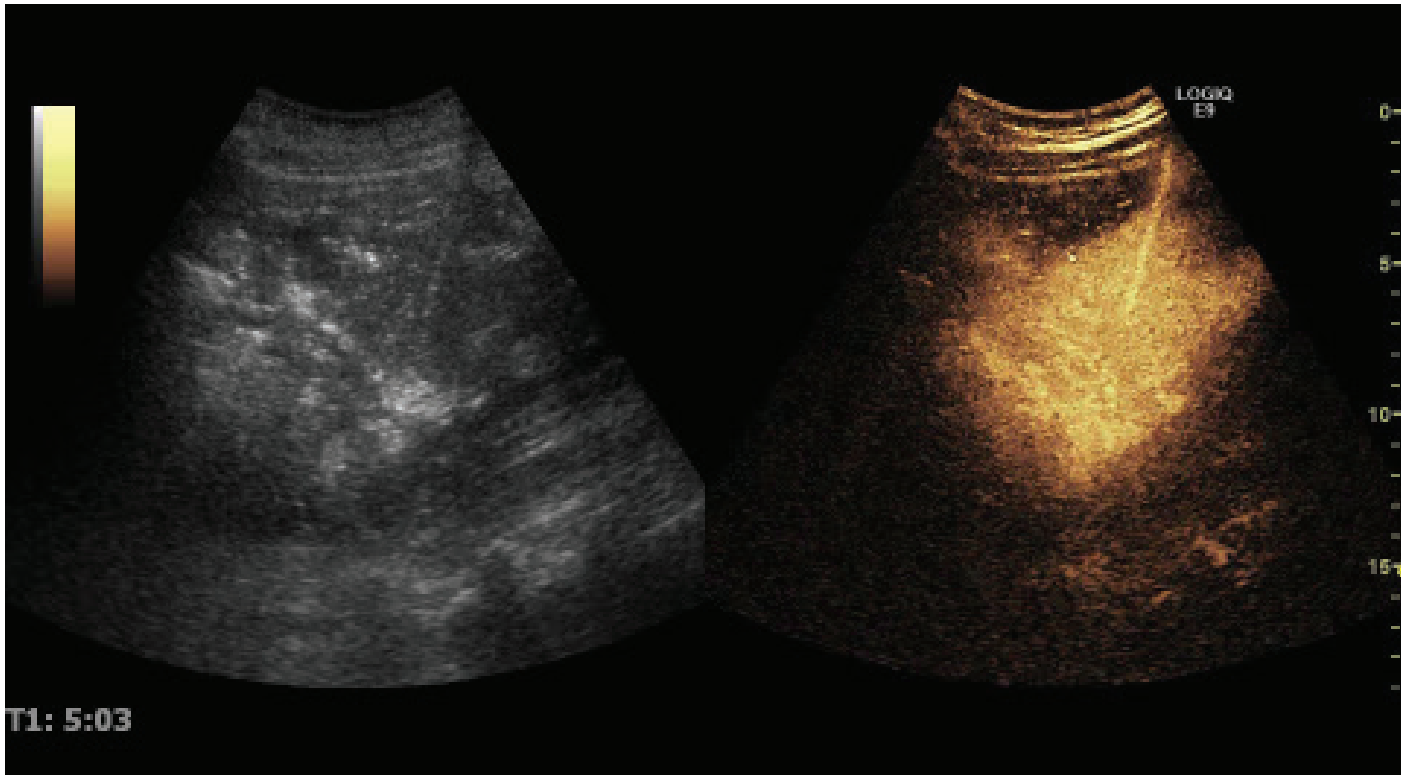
CEUS fistulography on catheter. Ultrasound image of a contrast enhanced ultrasound examination of a fluid collection in the pancreatic region on a patient with acute pancreatitis obtained with simultaneous dual display technique. As is the case with Figure 3 the picture to the left is a fundamental i.e. “normal” ultrasound scan and the picture to the right is a second harmonic scan obtained at the exact same place and time. Both scans are obtained using low mechanical index setting to avoid bursting the bubbles in the contrast agent, which accounts for the darker than usual appearance. A 7.5 F pigtail catheter has been inserted under ultrasound guidance and Sonovue[®] ultrasound contrast agent is injected through the catheter. In the harmonic image to the right, both catheter and cavity is filled with a solution of Sonovue[®] and stands out clearly delineated as opposed to the fundamental image to the left where it is difficult to outline both cavity and catheter.
